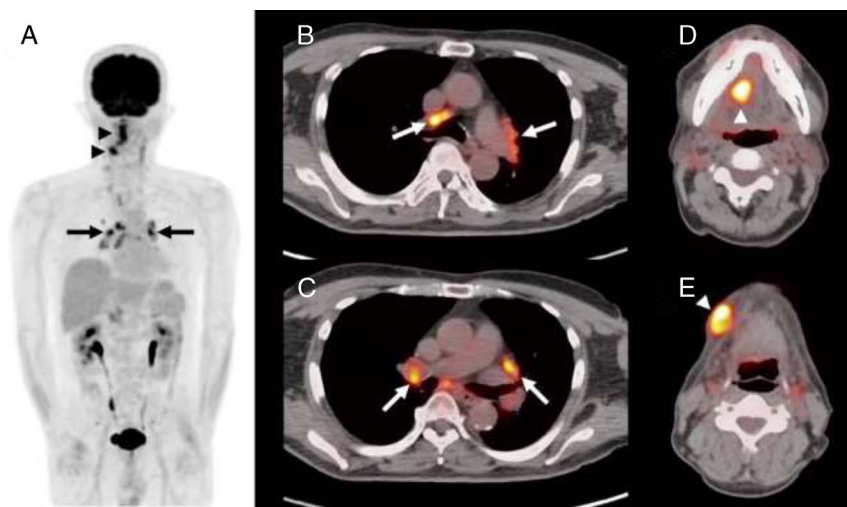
A 68-year-old man with tongue cancer and sarcoidosis underwent high-dose-rate interstitial brachytherapy to the primary cancer lesion (54 Gy/9 fr). Ten days later, ^{18}F -FDG PET revealed high FDG uptakes in the mediastinal and hilar lymph nodes, suggesting active inflammation in a sarcoidosis granuloma (A–C, arrows; SUV_{max} 8.05). In addition, ^{18}F -FDG uptake was also seen in the pathway of the applicator implantation and radiation-induced inflammation, which was not observed in the pretreatment ^{18}F -FDG PET (D and E, arrowheads). Uptake in the primary tumor region was not clear.
